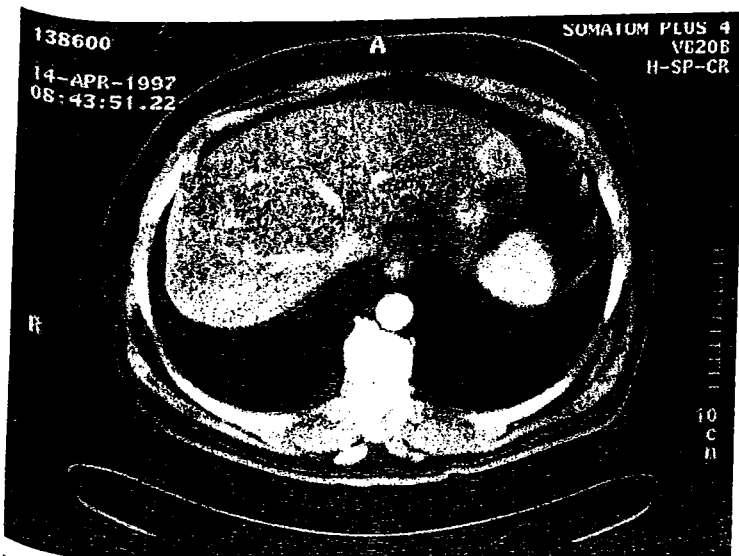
Computed tomography scan showing a metastasis in segment III.
